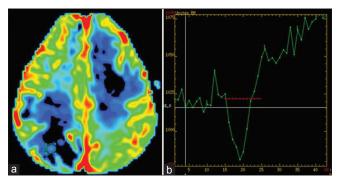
The perfusion magnetic resonance imaging allowed a color mapping of the relative cerebral blood volume relative cerebral blood volume in (a) with hypoperfusion, while the perfusion curve demonstrated to be above the threshold after the first bolus passage (b)
